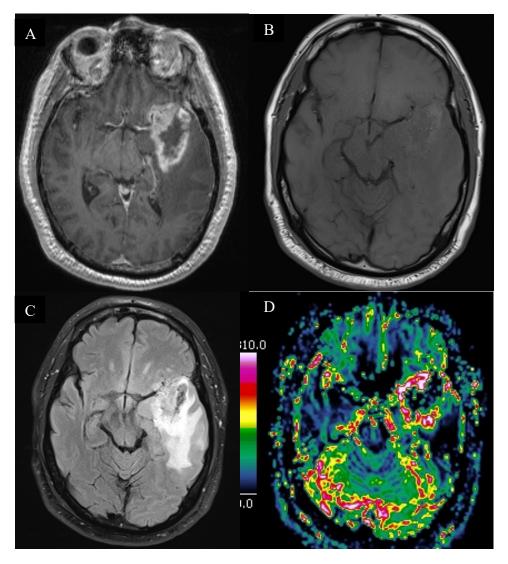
A-D) Glioblastoma WHO grade IV. Axial T1w with (A) and without Gd contrast (B), /FLAIR (C) and perfusion MRI (pMRI) (D). Demonstrate a heterogenous contrast enhancing tumor (A) with a cystic/necrotic center (A) and surrounding peritumoral vasogenic oedema (C) in the left temporal lobe. The pMRI (D) demonstrate increased cerebral perfusion in the contast enhancing parts of the tumor.
